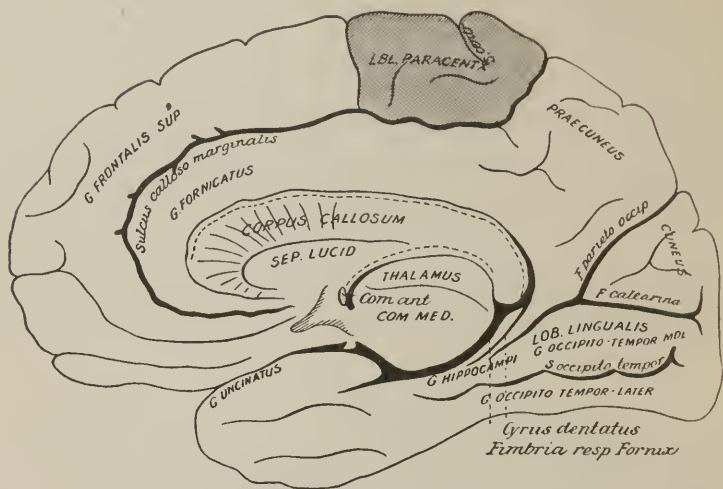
ASPECT OF THE MEDIAN SURFACE OF THE CEREBRUM, AS IT APPEARS WHEN THE TWO HEMISPHERES ARE SEPARATED.—(After Ecker.)
